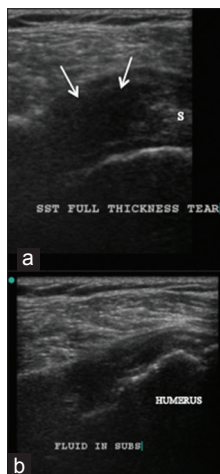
A 66-year-old male presented with complaints of gradual restriction of movements of the right shoulder. There was history of fall on the right shoulder 1 year back. (a) Transverse sonogram of the right supraspinatus revealed full-thickness hypoechoic defect at the normal location of the supraspinatus tendon (white arrows). Fluid was seen within the defect and extended from the articular surface to bursal surface. The torn edge of the retracted supraspinatus tendon could be seen (S); and (b) Transverse sonogram of the right subscapularis tendon demonstrated full-thickness tear of the tendon
